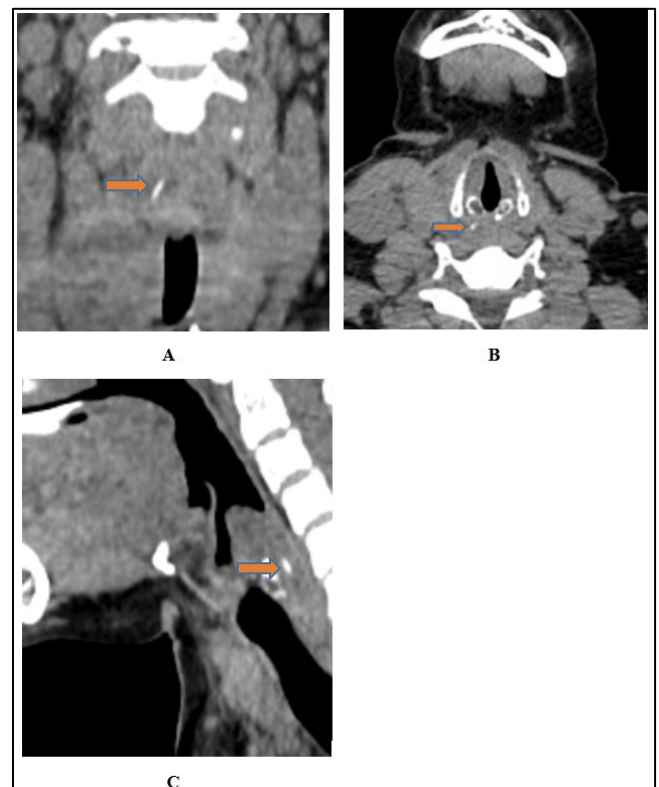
CT neck revealed a linear hyperdense FB in the posterior wall of hypopharynx, measuring 2.2 cm in length as visualized in axial (A), coronal (B) and sagittal view (C)
